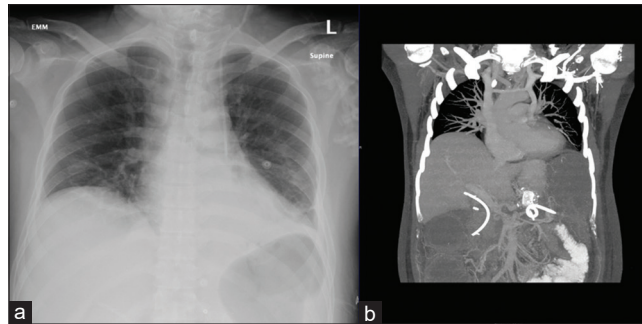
(a) Chest X-ray showing unusual path of the left internal jugular central line. (b) CT chest showing Duplex superior venacava
